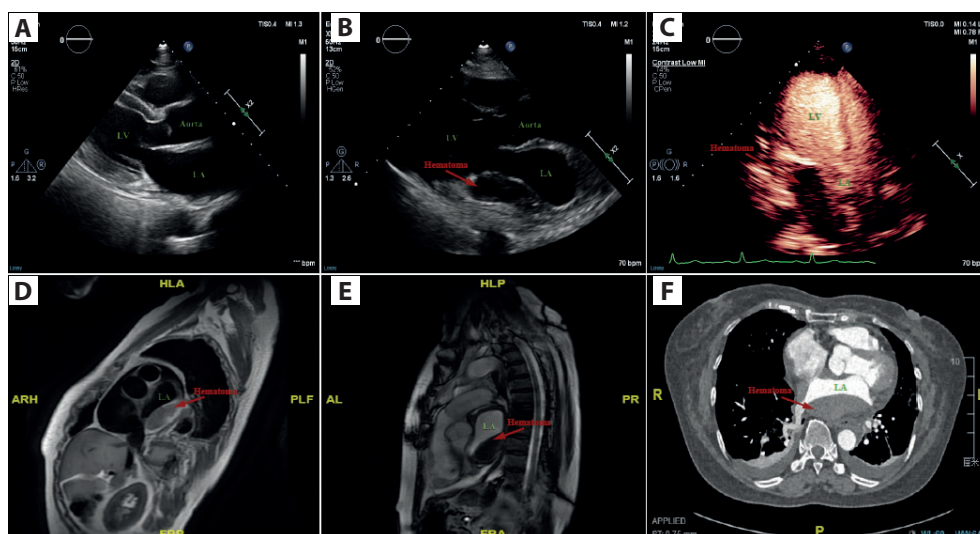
A. The preoperative transthoracic echocardiographic image. B. The postoperative transthoracic echocardiographic parasternal long-axis view showed a hematoma (indicated by the arrowhead) in the posterior wall of the left atrium. C. Myocardial contrast echocardiography image of the hematoma (the arrowhead). Dual inversion recovery black-blood MR sequences D. Dual inversion recovery black-blood MR sequence. E. Cine CMR: SSFP cine sequence (FIESTA). F. Postoperative CTA of the intramural hematoma (indicated by the arrowhead)
